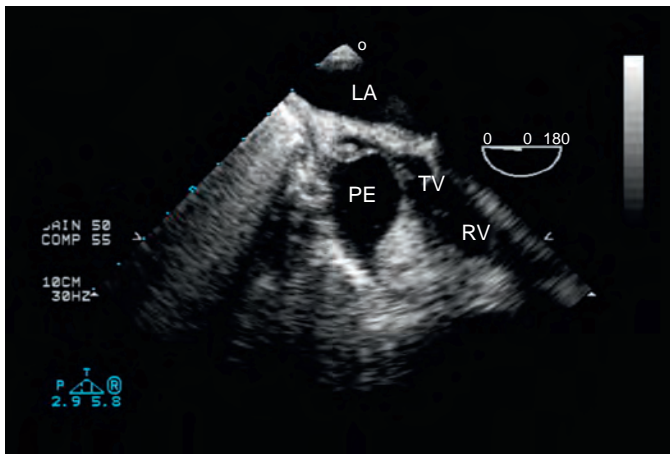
Intraoperative midesophageal four-chamber transesophageal echocardiographic (TEE) view of a patient with bilateral pleural effusions, thought to be secondary to metastatic breast cancer, performed for the diagnosis of severe refractory hypotension after induction of anesthesia. A loculated pericardial effusion (PE) is nearly completely obliterating the right atrium and causing a cardiac tamponade. Based on the TEE diagnosis it was possible to add a video-assisted thoracoscopic surgery pericardial window to the originally planned surgery. LA, Left atrium, RV, right ventricle; TV, tricuspid valve.
